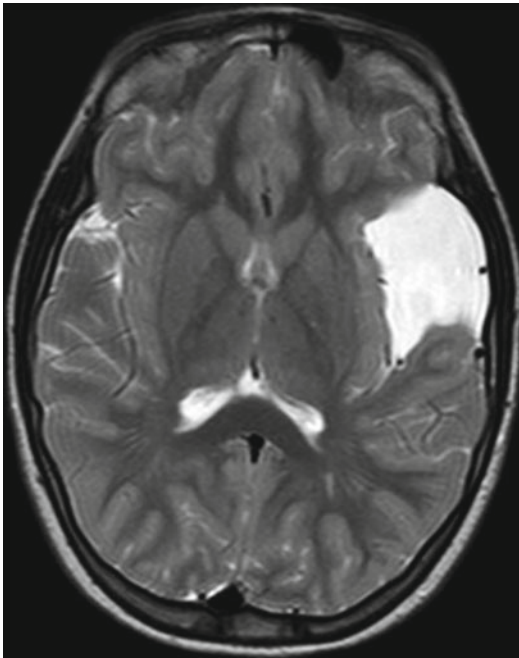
Axial T2w MRI of left medium-size Sylvian cyst showing no mass effect on the adjacent cerebral parenchyma. This patient was followed for 4 years after diagnosis, and neither symptoms nor signs which could be referred to the lesion were exhibited by the patient during that period
